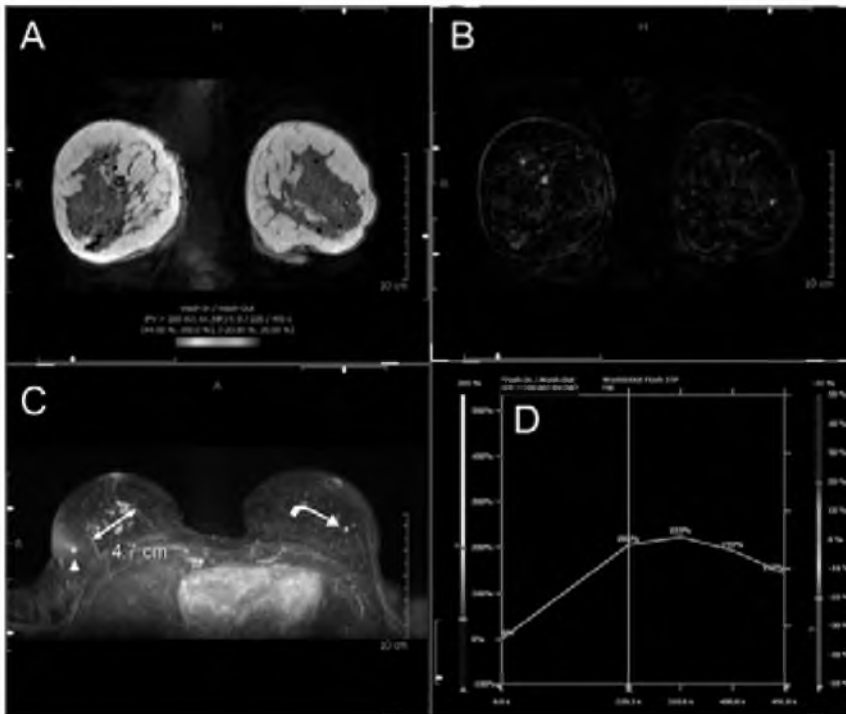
MRI beelden van een 40-jarige vrouw met een sterke familiar belasting, die zich presenteerde met tepelvloed. Het mammogram liet dens klierweefsel zien met multipale benigne calcificaties en was dus negatief (niet afgebeeld). Microdochectomie liet LCIS zien. Vervolgens is een MRI verricht, waarop een multifocaal ILC over een gebied van 4.7 cm zichtbaar is. Hoewel het grootste deel van de tumor continue aankleuring liet zien, was er toch een klein gebiedje waar het contrast snel uitwaste. (A: T1w FLASH 3D acquisitie met hieroverheen een kleur gecodeerde map van de aankleuring (zie hoofdstuk 10 voor een afdruk van dit figuur in kleur), de cursor is geplaatst op het door het computerprogramma gedetecteerde punt met de meest verdachte aankleuringcurve, B: subtractie beeld van pre- en postcontrast MRI, C: maximale intensiteit projectie, hierop is het tumor gebied (dubbele pijl) duidelijk zichtbaar. Voorts is er een lymfe klier in de rechter mamma zichtbaar (pijlkop) en een fibroadenoom in de contralaterale borst (gebogen pijl). D: door de machine gedetecteerde meest verdachte aankleuringcurve (corresponderend met de cursor in A)).
